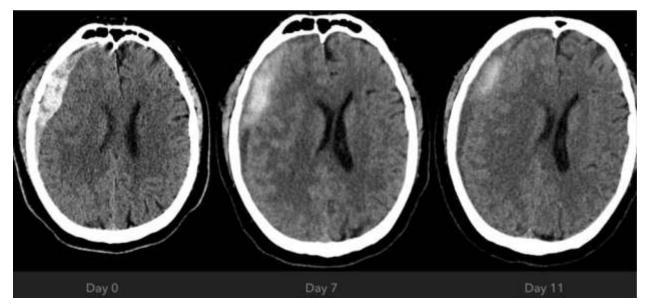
Follow up of SDH following surgical evacuation and EMMA: (a) Non-contrast CT
